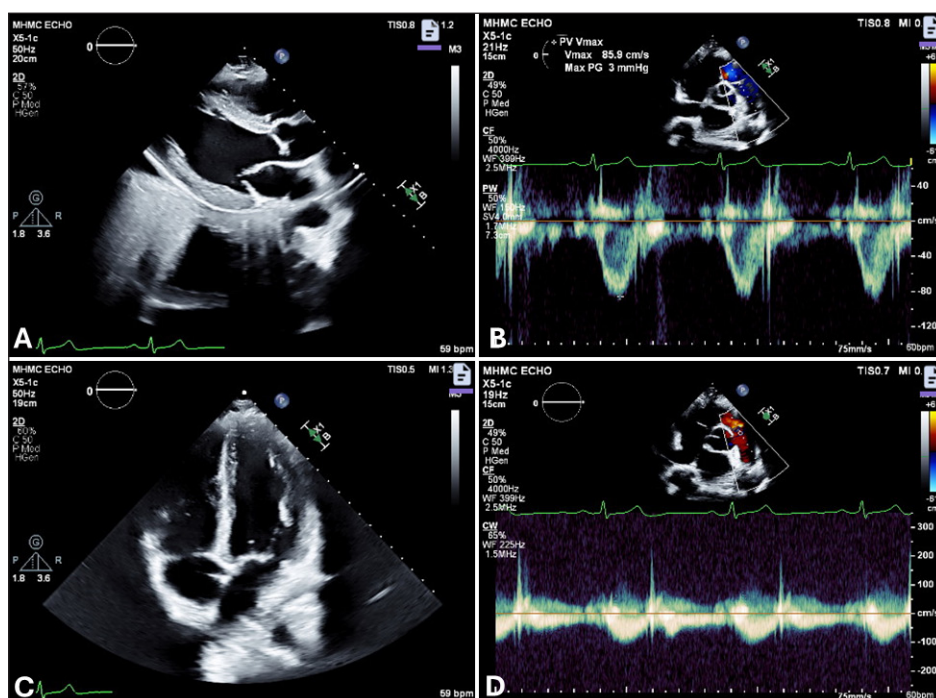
Echocardiography demonstrating preserved left and right ventricular systolic function.
